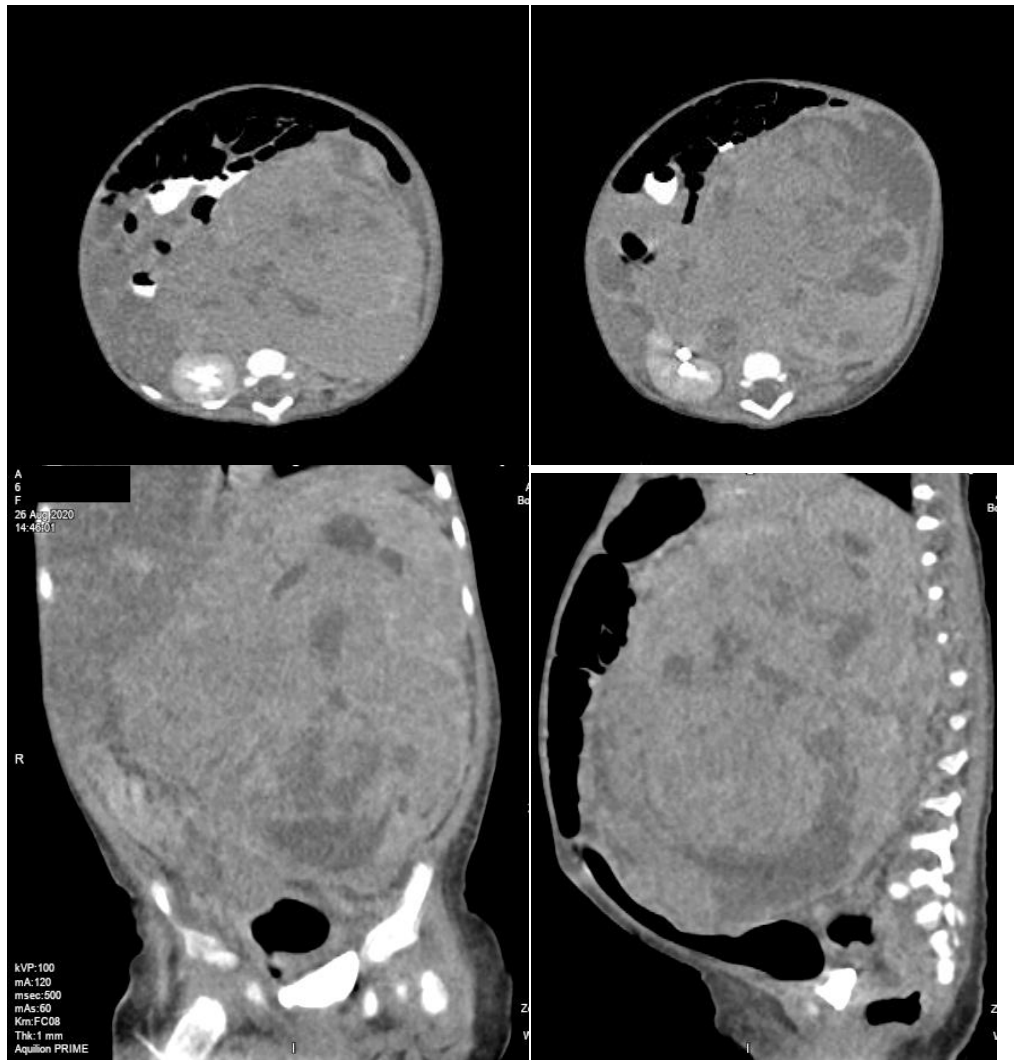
Shows an axial, coronal and sagittal post IV contrast CT images of a 6month old baby showing huge multilobulated retroperitoneal mass lesion suggestive of nephroblastoma. The patient has a history of abdominal swelling and abdominal mass on ultrasound.
